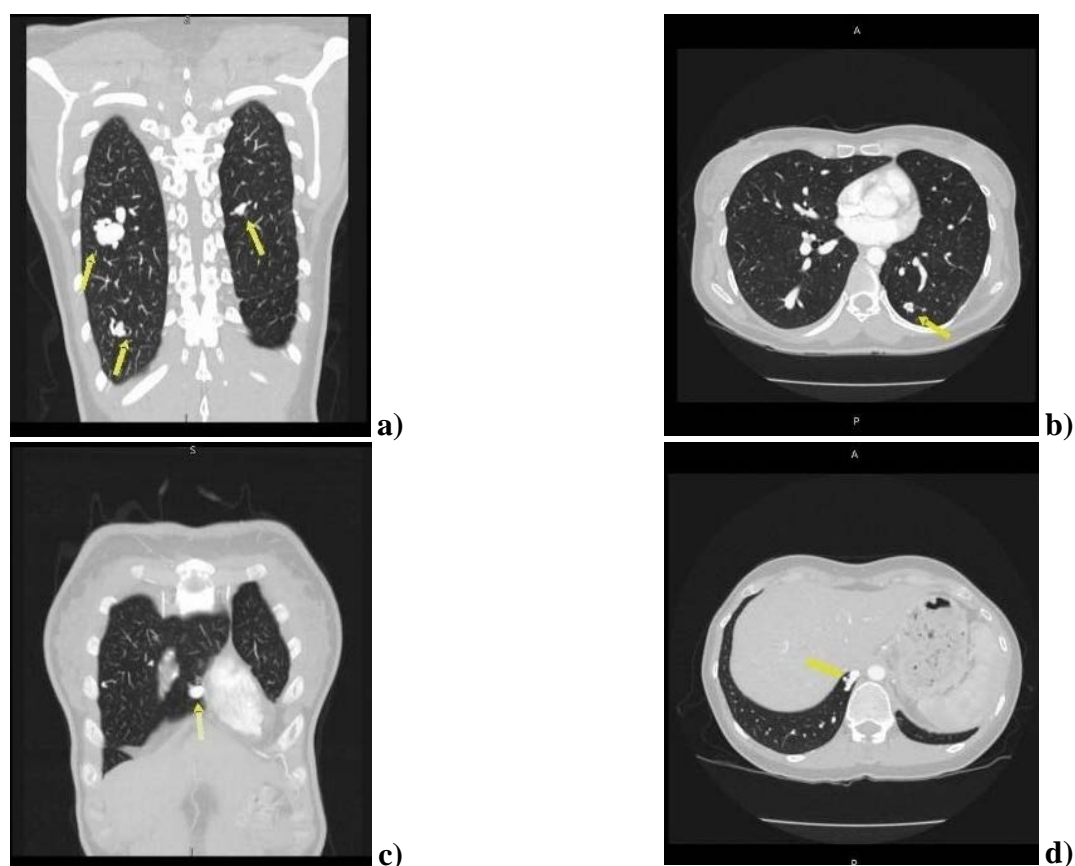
(a–d) – Multislice computed tomography with pulmonary angiography (MSCT PA) finding shows many pulmonary arteriovenous malformations (PAVMs) in lung parenchyma on both sides.
